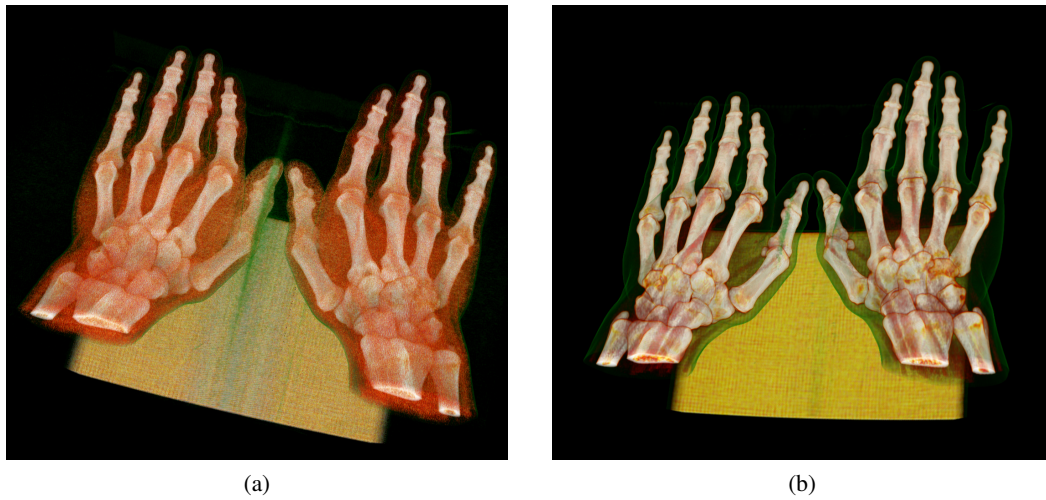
(a) CT volume no. 1 before and (b) after filtering with a Gaussian kernel to reduce image noise.
